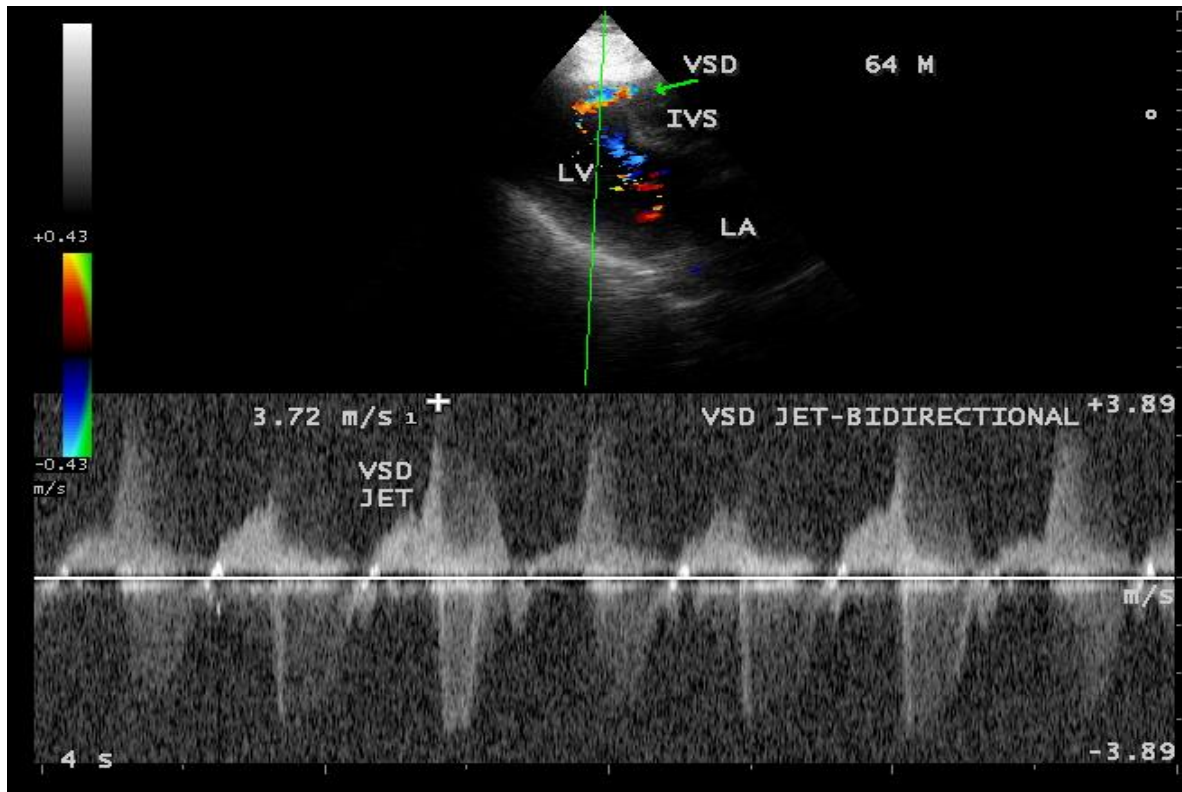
CW (Continuous Wave Doppler) showing the bidirectional jet of ventricular septal rupture (VSR).
